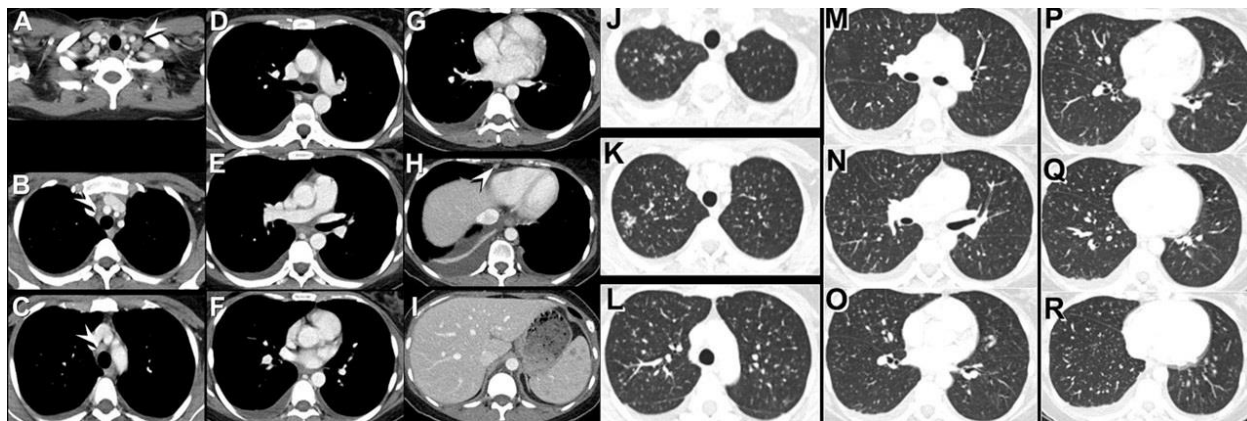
Axial enhanced chest CT displayed in soft tissue (A-I) and lung (J-R) windows.
